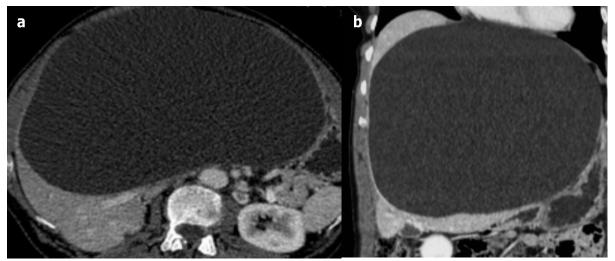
Very large hepatic simple cyst in a symptomatic 64-year-old female patient with abdominal pain. (a) Axial and (b) coronal computed tomography at portal-venous-phase shows a very large hepatic simple cyst. The cyst had been progressively growing for a number of years and has been finally treated by laparoscopic fenestration with an improvement of pain.
